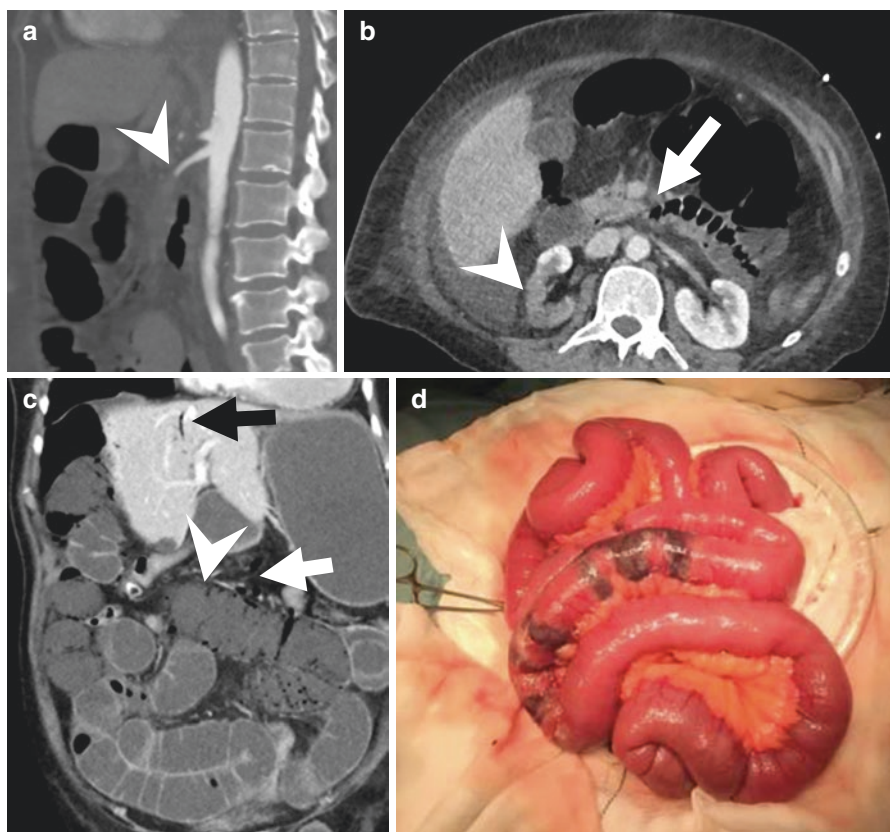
A 77-year-old female with atrial fibrillation presented with acute abdominal pain. (a) Sagittal CT shows abrupt occlusion of the SMA 2 cm from its origin (*arrowhead*). (b) Axial CT identifies total occlusion of the proximal SMA (*arrow*) and infarction of the right kidney (*arrowhead*). (c) Coronal CT demonstrates diffuse small bowel dilation. There is evidence of thinning of the small bowel wall, hypoenhancement and pneumatosis (*arrowhead*), portomesenteric gas (*white arrow*), and intrahepatic portal venous gas (*black arrow*) consistent with ischemia. (d) Intraoperative image demonstrating multifocal regions of ischemia of the jejunum correlating to the region of pneumatosis identified on preoperative CT
